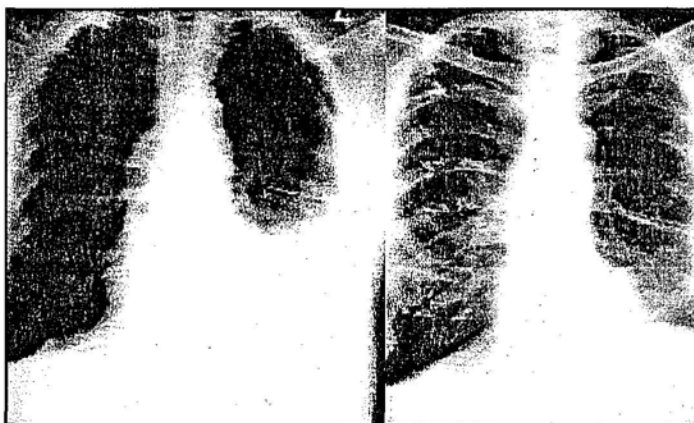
Chest X-ray at the beginning and two weeks with the use of device
